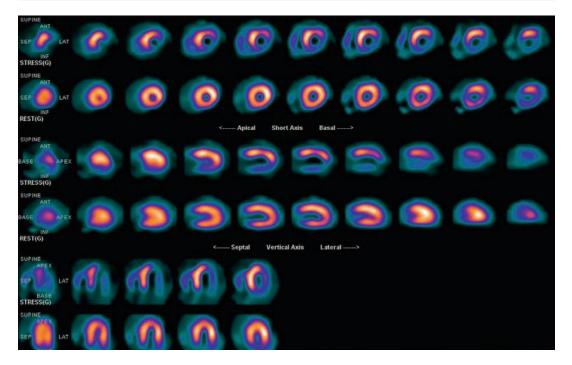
Representative single-photon emission computed tomography myocardial perfusion imaging (SPECT MPI) demonstrating normal perfusion at rest (lower images in each series) and a perfusion defect after stress (upper images
